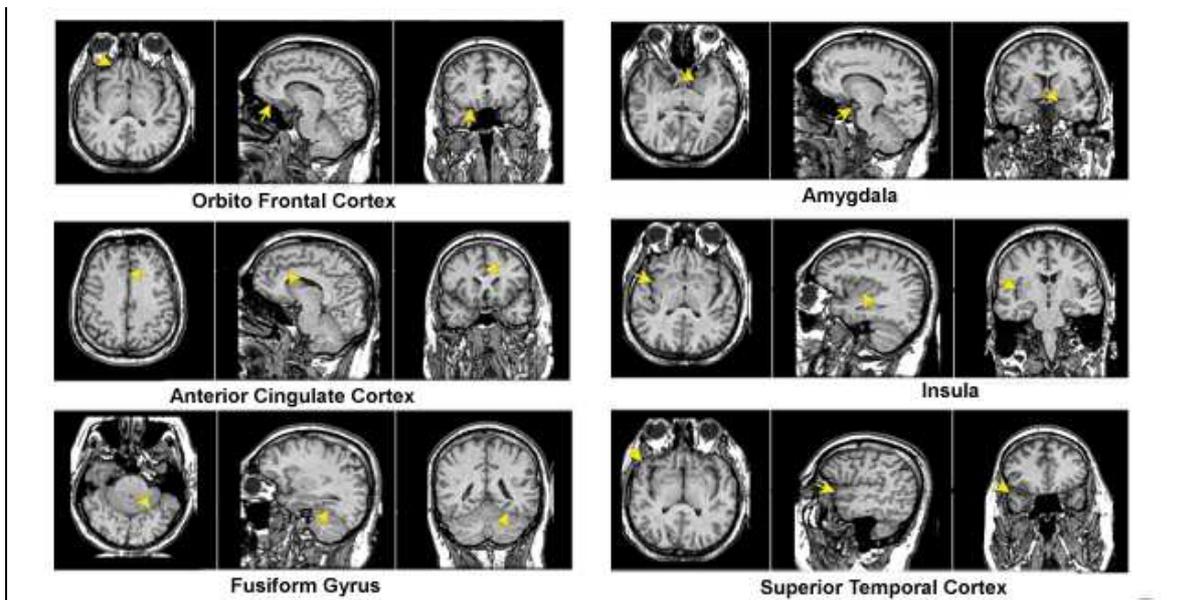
Magnetic resonance images showing several neural structures involved in face processing.
